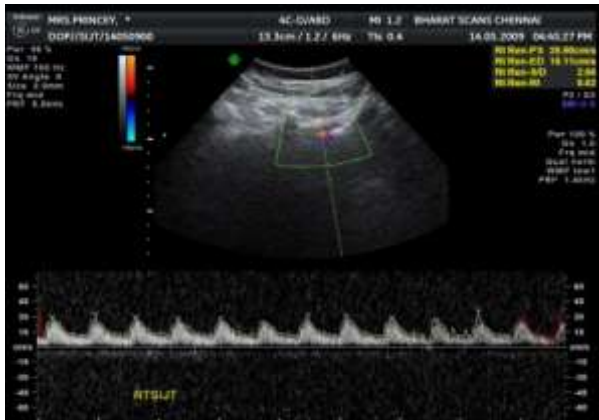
Doppler showing Rt. Colour flow
